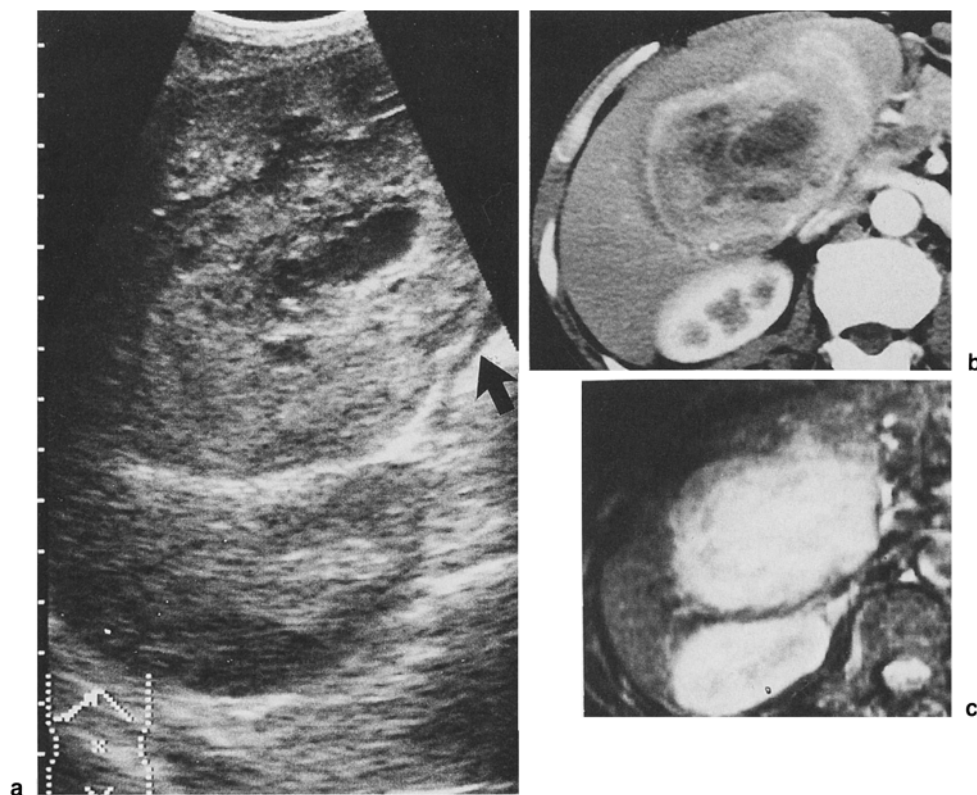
a Ultrasonography reveals a well-circumscribed, heterogeneous tumor, 8cm in diameter, in the hepatic hilum, compressing the posterior branch of the portal vein (*arrow*). b Dynamic computed tomography. The tumor was enhanced by contrast medium in the rapid phase, (35s after contrast injection) except for a central area consistent with necrosis. c Magnetic resonance imaging of the T2-weighted image
